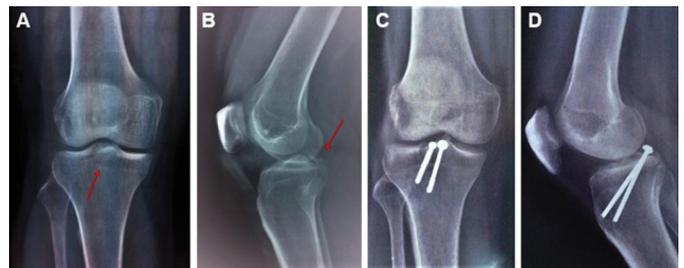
Preoperative AP X-ray of a right knee showing the fracture line (red arrow) (A), preoperative lateral X-ray showing the avulsed fragment line (red arrow) (B), the reduction and fixation of the fractured fragment at the AP X-ray (C) and lateral X-ray (D).
